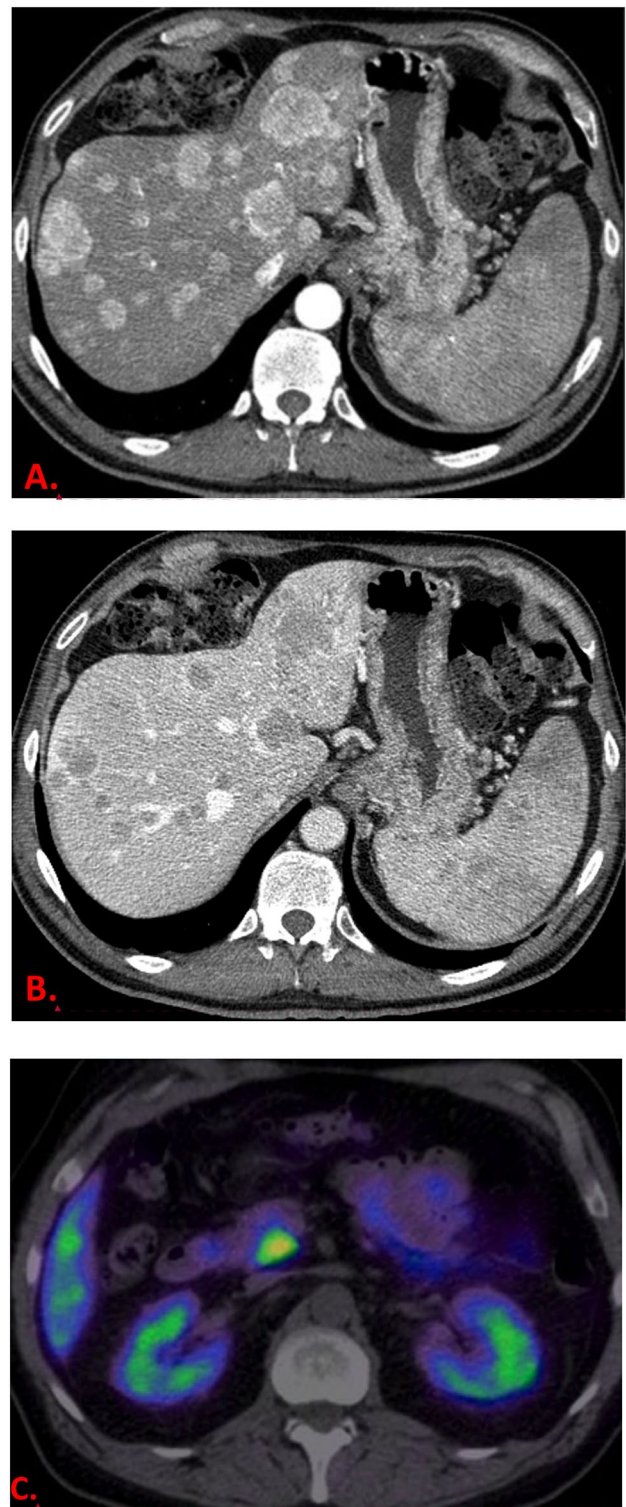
Representative images of NeLM on CT in Arterial (A) and Portal Venous (B) phase as well as (C). DOTATATE scan demonstrating avidity in uncinate, which is physiologic
